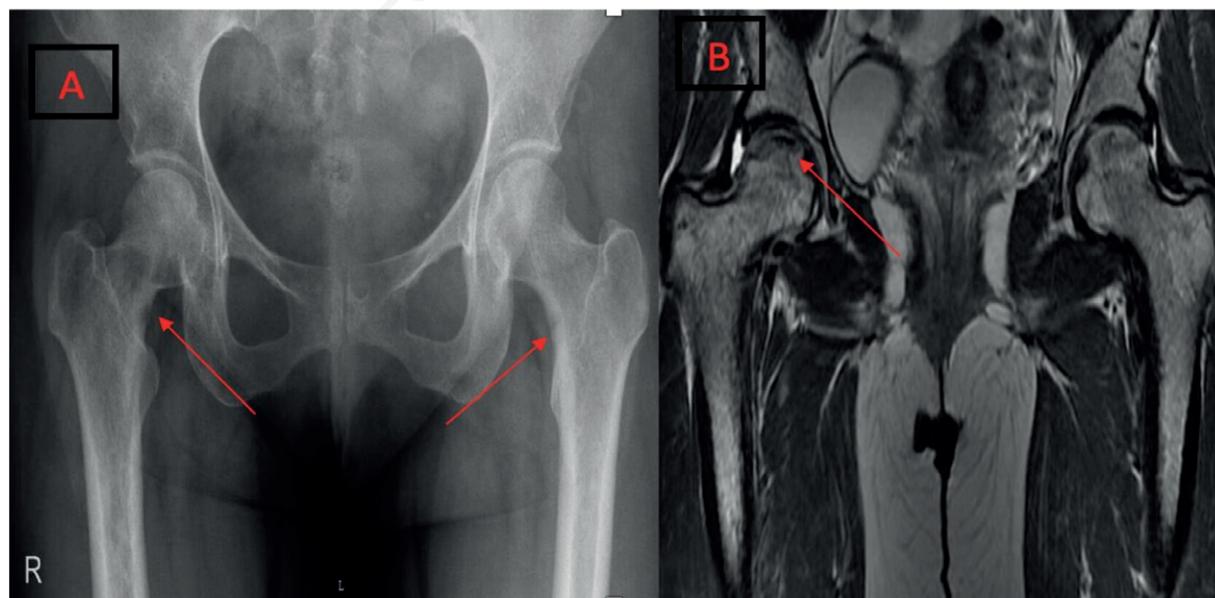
Imaging characteristics of Case #2: A) x-ray pelvis showing pseudo fractures in neck of femur; B) magnetic resonance imaging of the pelvis showing avascular necrosis of femoral head.
